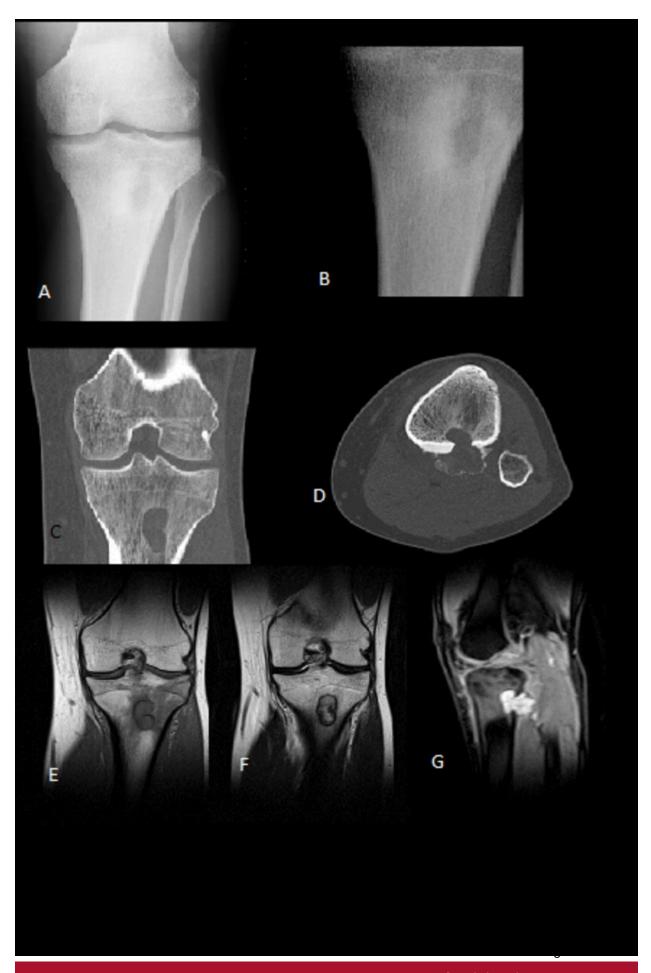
Osteoblastoma. Frontal radiographs (A,B) show a lytic lesion with sclerotic pheripheral rim in the tibia. Coronal and axial computed tomography reformations (C, D) reveal a metaphyseal eccentric cortical lesion with calcified matrix. This lesion presents isointensity of signal on T1-weighted images (E) and slightly hyperintensity of signal on T2-weighted images (F), with surrounding bone marrow oedema. After gadolíneo administration (G) the lesion presents homogeneous enhancement.
